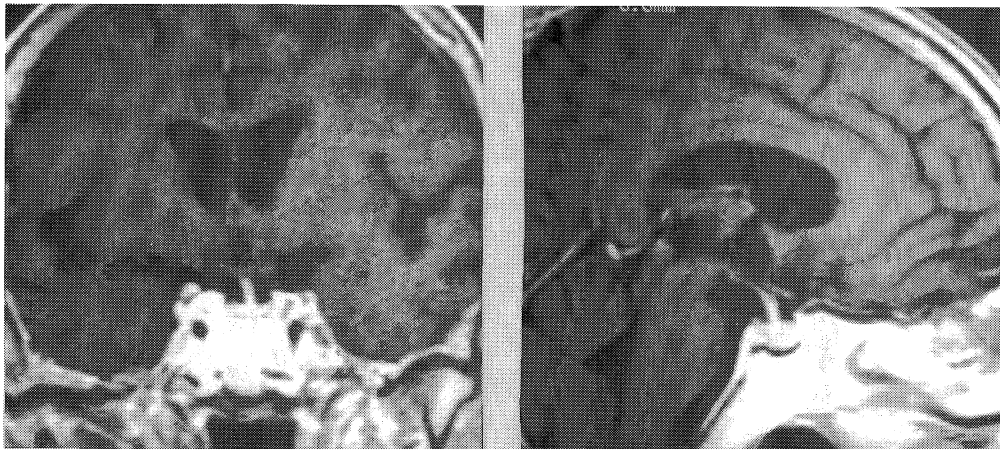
MRI of pituitary and hypothalamic region showed no tumor. Slight shifting of pituitary stalk to the left side was found, but no mass lesion was detected in the pituitary gland.
